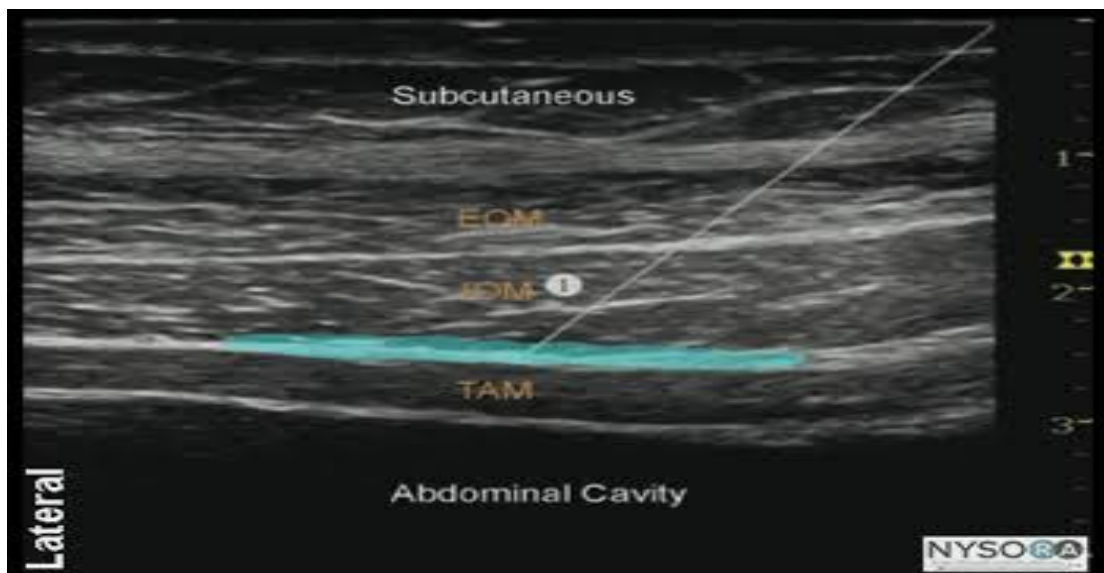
Ultrasound image of needle at the Transversus abdominis plane
